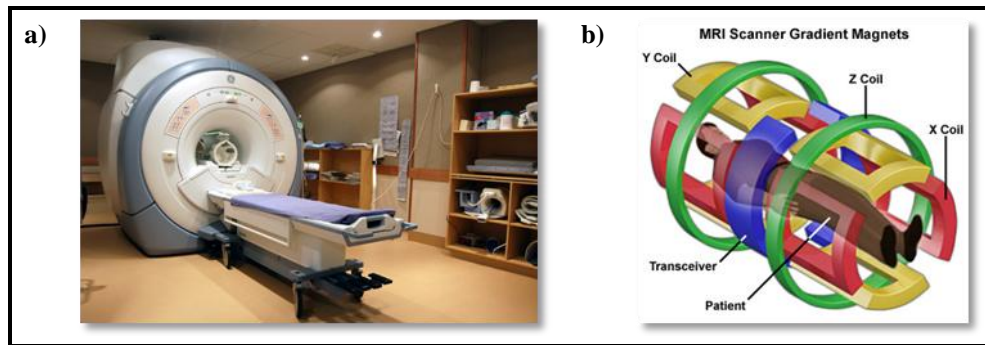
The GE 3T MRI machine
